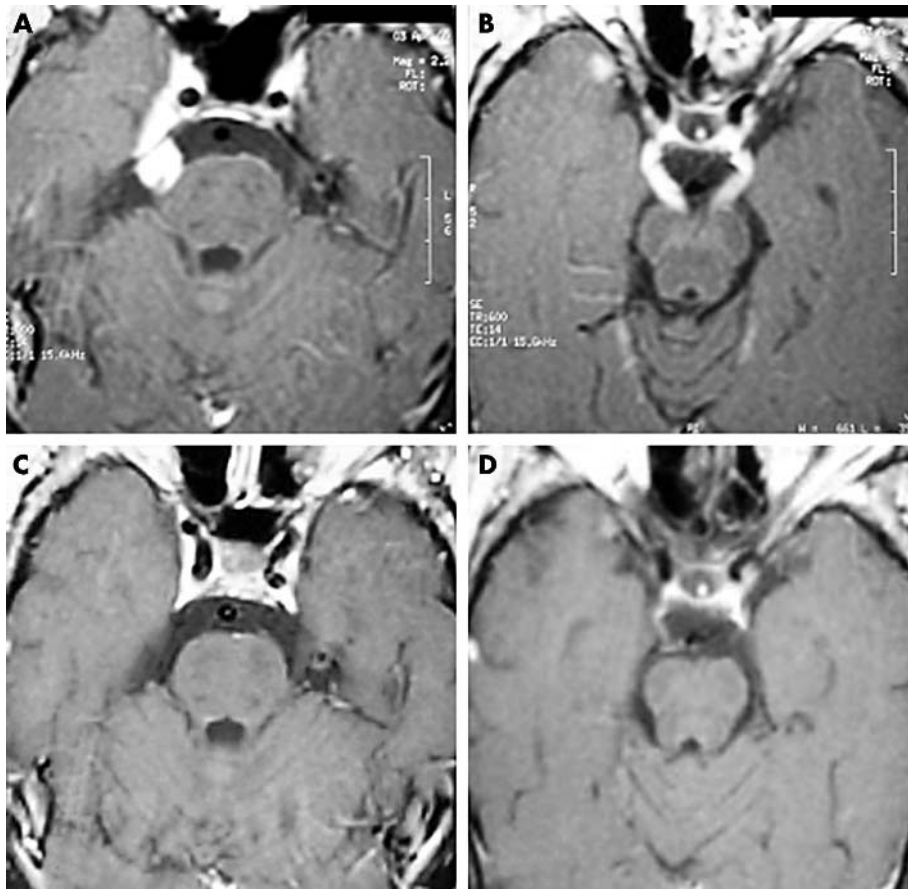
Brain axial T1 weighted MRI post gadolinium (Gd) administration. Post contrast images show an impressive enlargement and Gd enhancement of right cranial nerve V (cisternal and Gasser ganglion segments) (A) and of the III cranial nerves (cisternal segment) (B). Three months after starting highly active anti-retroviral therapy, there is no Gd enhancement of the V cranial nerve (C), and the right III cranial nerve shows only slight Gd enhancement (D).
